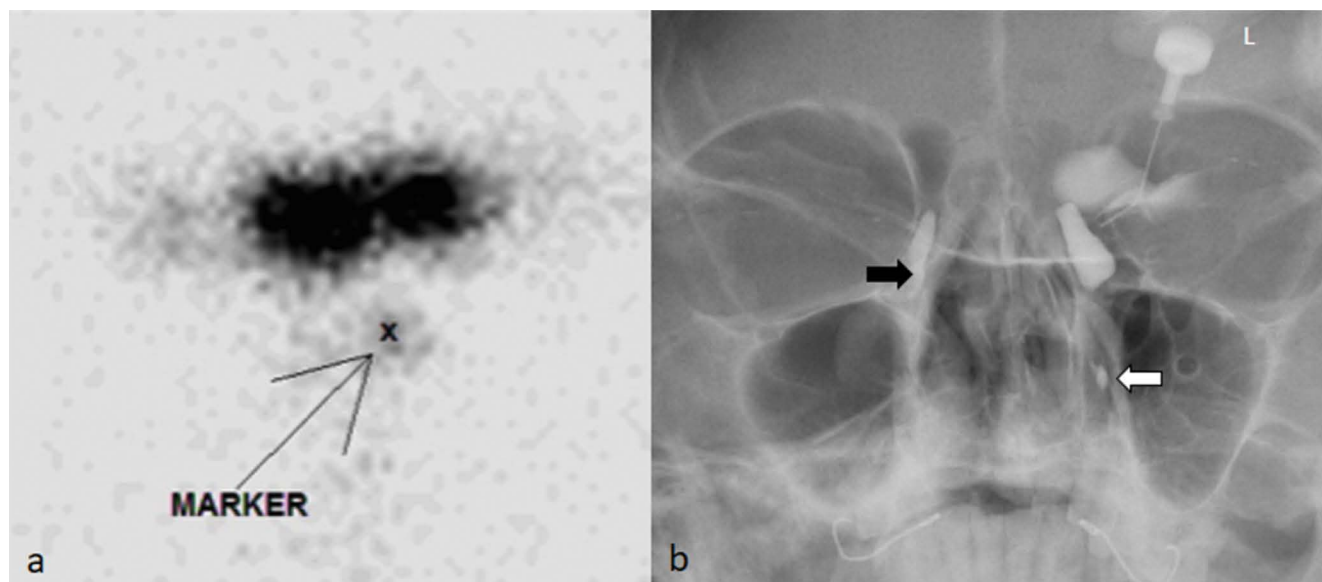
a) Dacryoscintigraphy showed obstruction in both systems; b) dacryocystography showed obstruction only in the right lacrimal drainage system (black arrow). The contrast flowed through the inferior meatus of the left lacrimal drainage system (white arrow)
